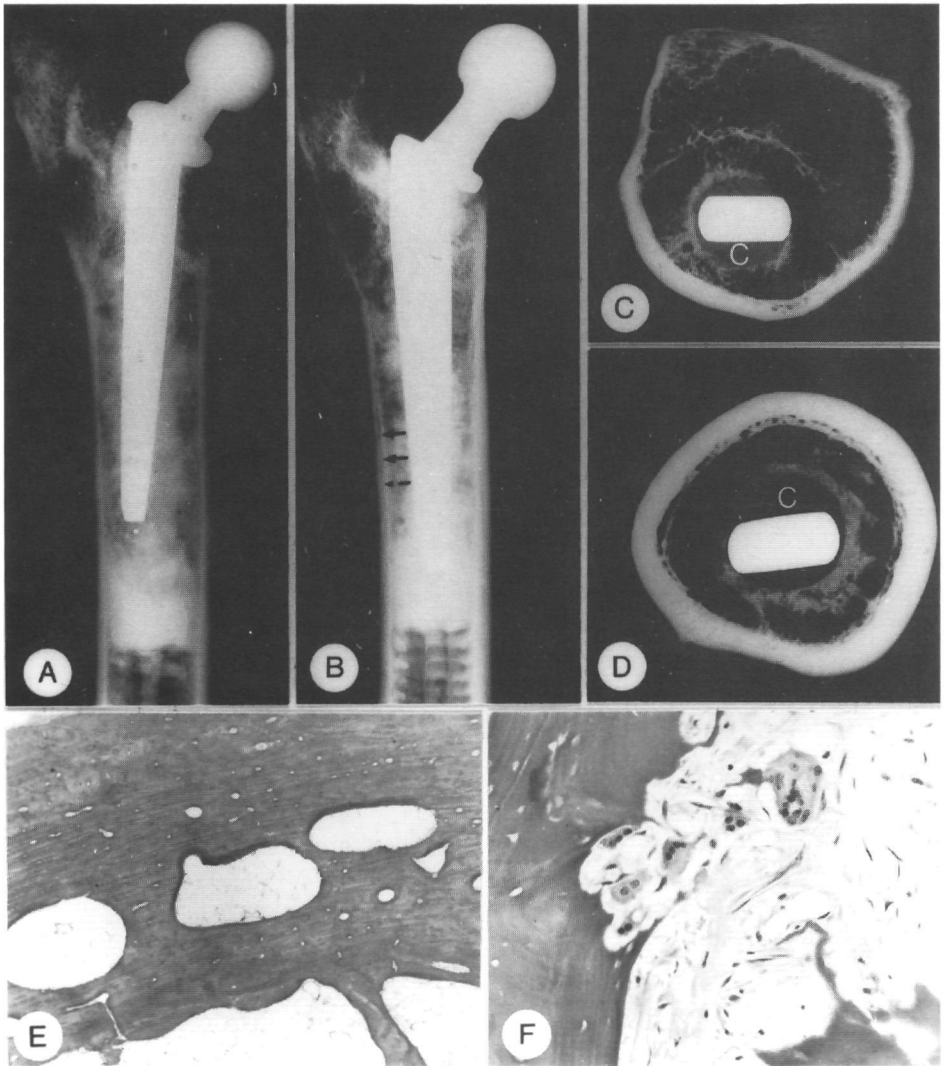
A and B* Roentgenograms of prostheses after six and twelve weeks, respectively. Note in *A* the change in trabecular appearance between the lateral proximal and more distal regions around the prosthesis. *B* Locally a radiolucent reactive line is present in the cortical bone (arrows). *C* and *D* Roentgenograms of thick sections of the proximal (*C*) and mid shaft level (*D*) of the femur after 12 weeks. Note the orientation of the trabeculae from the cement layer (*C*) to the preexisting cortical host bone. *E* and *F* Microphotographs. *E* shows cortical porosis (x30). *F* Local osteoclastic resorption of the graft. Note empty osteocyte lacunae (x250).
